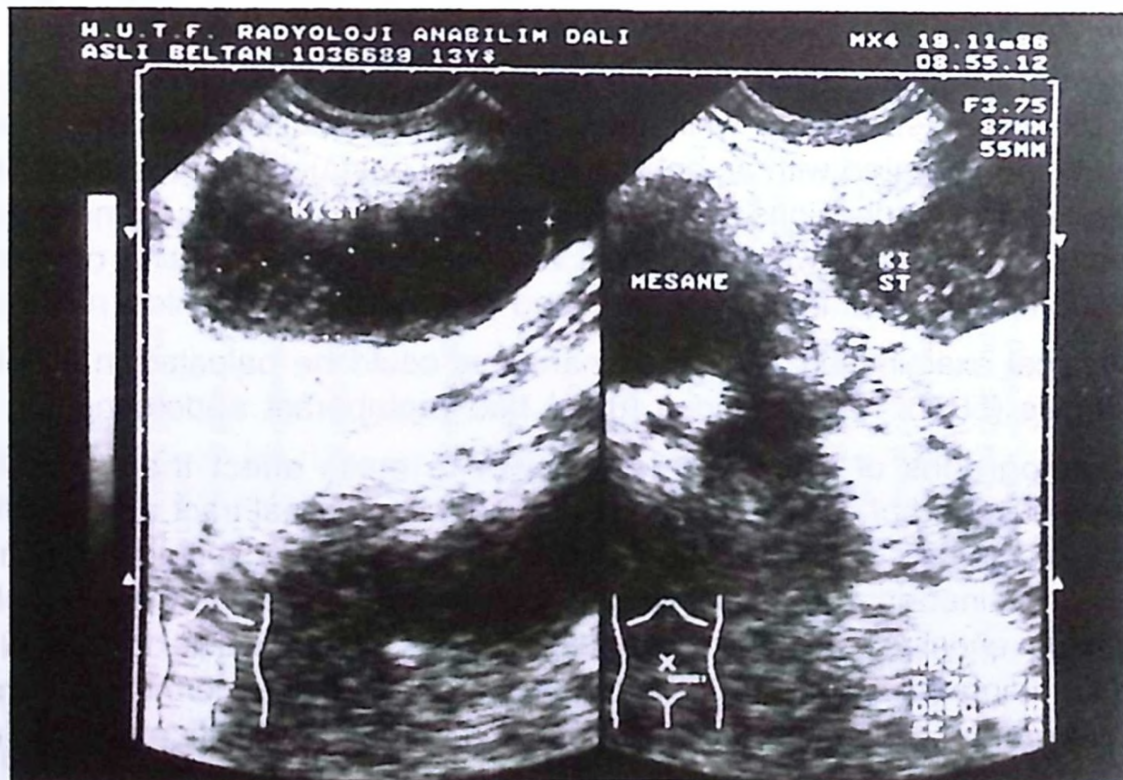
Abdominal ultrasonography showing an intraabdominal cystic mass filled with fluid.
